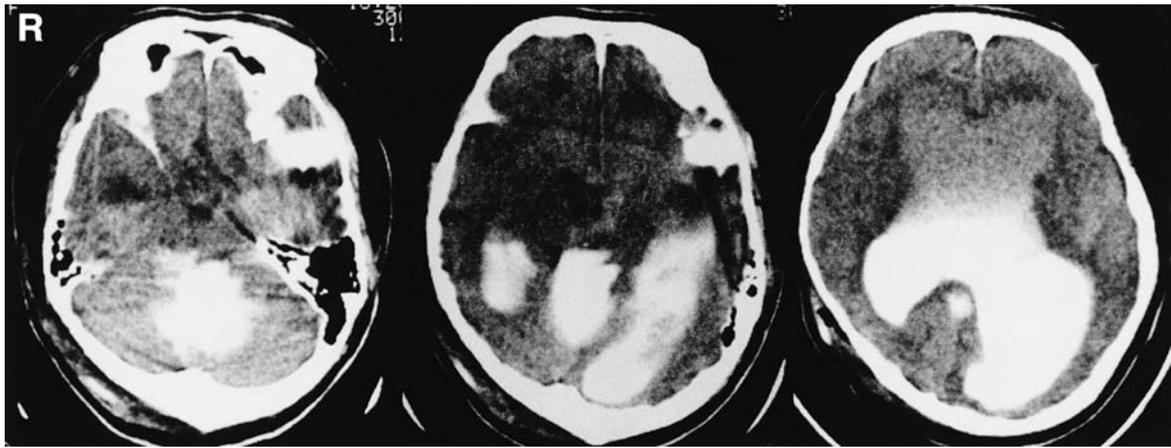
Computed tomography cisternograms 3 hours after injection of contrast medium into the right lateral ventricle demonstrating rapid filling of the arachnoid cysts in the left middle and the posterior fossae.
